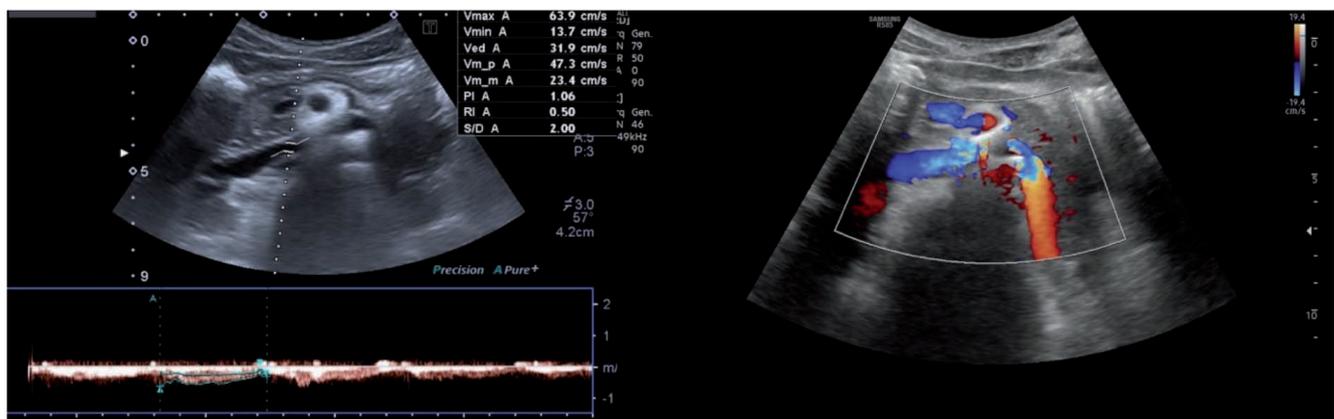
Patient 1: post-operative doppler ultrasound showing an unimpeded blood flow at the stent level.
